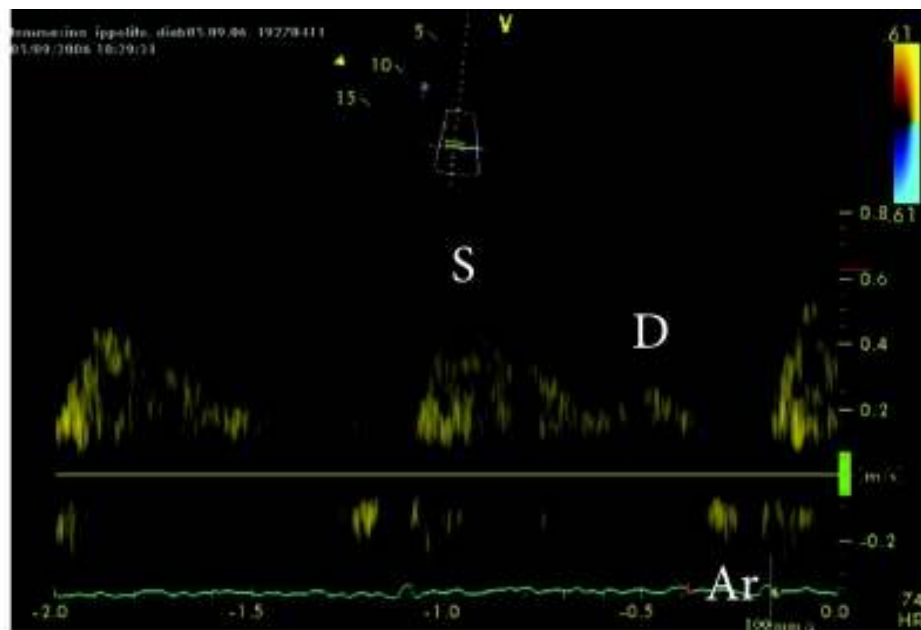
Pulmonary venous flow velocity by pulsed Doppler. ⁽¹⁵⁾
